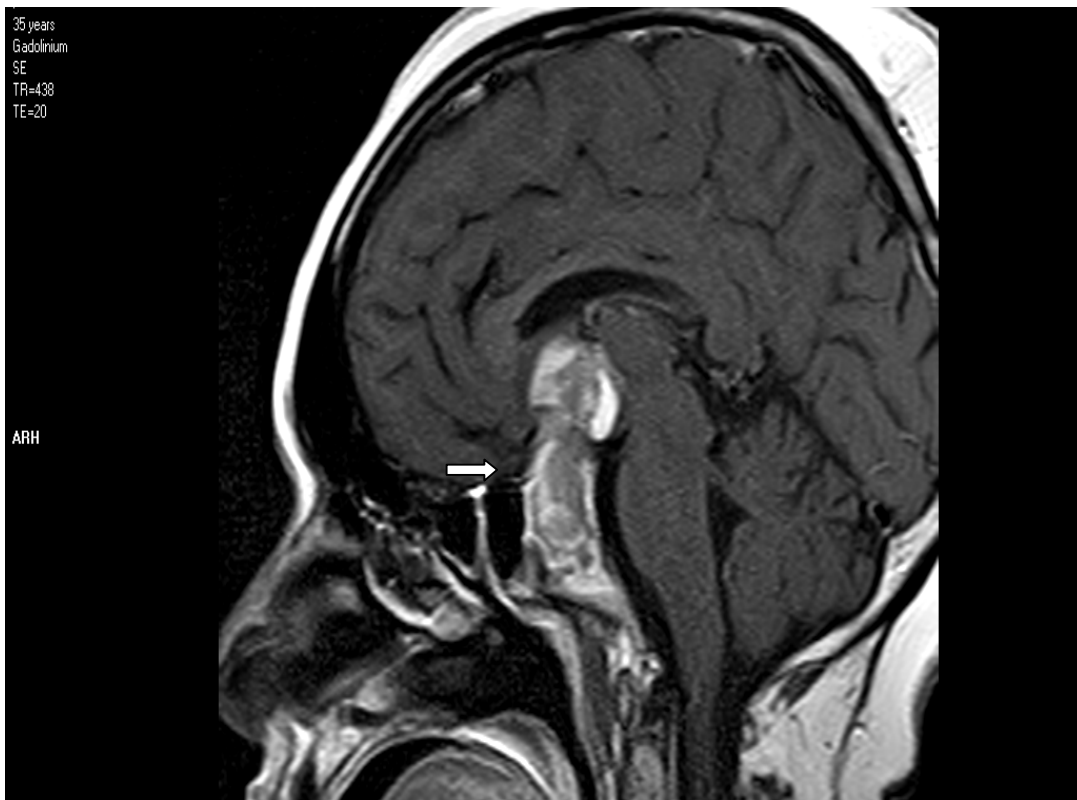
MRI Brain sagittal T1 WI with contrast showing macroadenoma for 35 years old female
